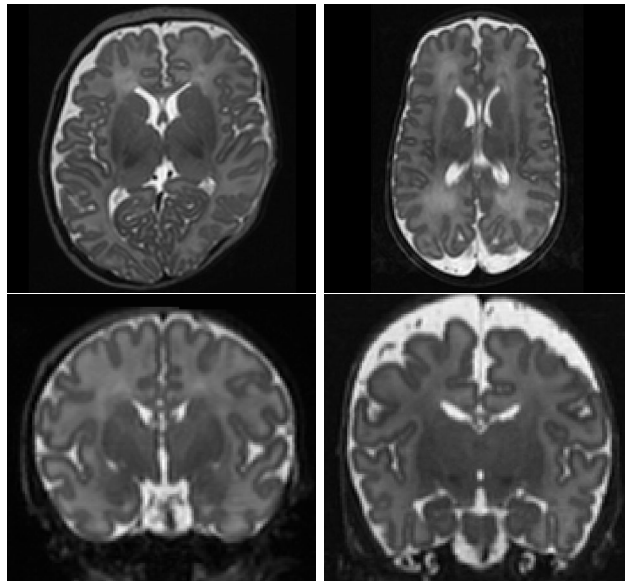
Representation of inter-subject variability in neonatal T2 weighted MRI. Images are term and preterm subjects extracted from the ALBERT dataset [Gousias et al., 2012]. First row, a term newborn (left) and a 28w born preterm acquired at the same age (right). Second row, two premature subjects at the same age (39w).
